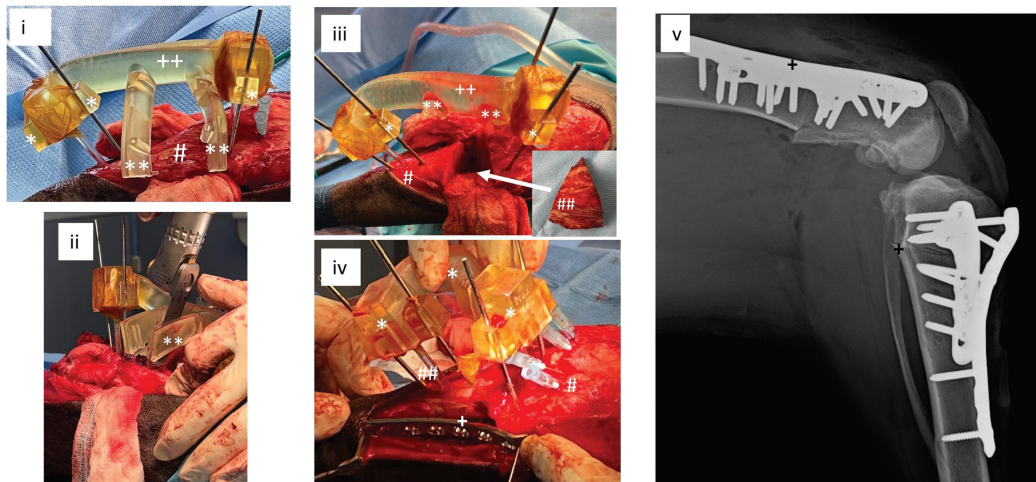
Case 1. Steps required to model and utilize the surgical components using traditional mesh modeling. (A) Pin set placement. For each bone segment to be isolated, a pin set was virtually implanted. The K-wires initially used for reference registration (i) are manually replicated and replaced with mesh model Steinmann pins (ii). A pin set handle is modeled with a stand-off distance from the bone surface (iii), which may be achieved via nonparallel pin sets, mechanical stops on the pins, or a physical spacer. Pin set handles have a unique shape that allows them to attach, detach, and reattach various jigs and guides. Each handle guides a pin set in a locally arbitrary orientation related to the engaged bone segment, but globally specific orientation, as it relates to the deformed bone. As such, pin sets must be placed simultaneously so that the global relationship to one another, and their engaged bone segments, is specific to the deformity. The virtual pins match the size of the pin (#) that will be used at surgery (iv) to attach to the pin set handle (\*\*). A third pin set was required in this case that had no reference K-wire pin set present and was therefore modeled virtually (\*) for future insertion via the initial pin placement jig (see series B). (B) Pin placement jig and cutting guides. A rigid pin placement jig securing all three pin handles, and corresponding pin sets, was modeled (i and ii) and used in surgery (iii). The jig ensures maintenance of global relationship if all associated pin sets engage bone bicortically. The pin set distal to the osteotomy is positioned relative to the proximal pin set with a spatial relationship that mimics the deformity. The location where the third pin set was modeled (#) and successfully placed at surgery (##). The pin placement jig also had two cutting guides modeled (\*) that were enclosed on at least three sides and can be seen at surgery (\*\*). The metal shield (^) can be seen secured to the cutting guide to avoid any fragments from the 3D components from forming. Cutting guides are modeled to attach to either a pin set handle or a jig. (C) Final alignment jig and implant guide. After virtual osteotomies have been performed and bone segments realigned, a repositioning jig was modeled that attaches to each pin set handle. This jig translates each bone segment via their corresponding pin set into final alignment and also has jig plate positioning and drill guides to facilitate placement of precontoured implants for definitive fixation. The final alignment jig can be seen modeled (i) and in surgery (ii). Postoperative lateral radiograph shows final alignment (iii).
